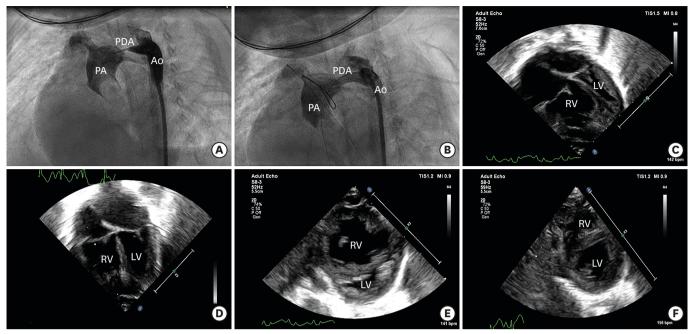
(A) Aortogram reveals an extremely narrowed and closing pulmonary end of the PDA. (B) Post-stenting aortogram shows a well-expanded stent. (C) End systolic frame from a baseline echocardiogram at presentation shows a squashed banana-shaped left ventricle on day 39 of life. (D) Apical 4 chamber view frozen in an end systolic frame showing IVS in midline. The LV was no longer banana-shaped. (E) At presentation, the baseline echocardiographic images in the parasternal short axis view at the papillary muscle level frozen in an end systolic frame shows an ellipsoid LV (classification from Leong et al.²) with the IVS pushed toward the LV. (F) Four days after stenting, the parasternal short axis view at the papillary muscle level frozen in an end systolic frame shows a well-expanded LV in a satisfactory configuration (classification from Leong et al.²) with the IVS pushed toward the RV.
